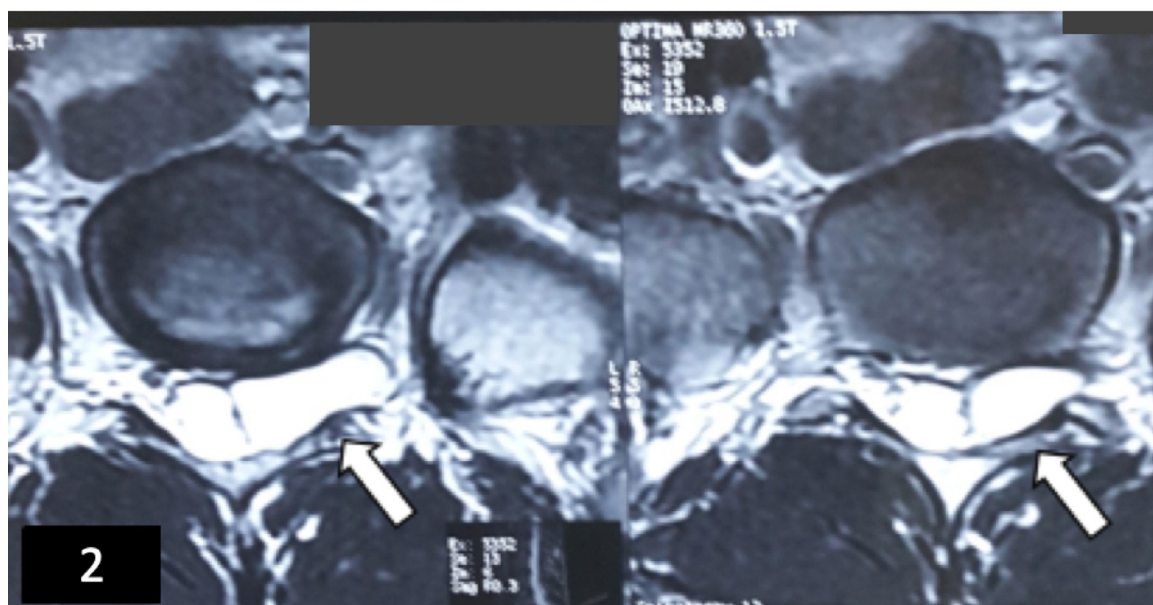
Axial T2-weighted image at L5-S1 level shows a left-sided cyst with extension to the foramen (white arrows).
